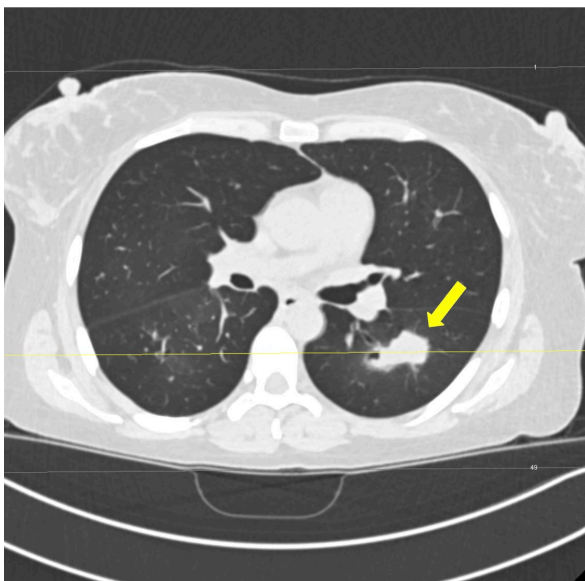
CT Chest: Transverse view of 3.8 cm nodule.
